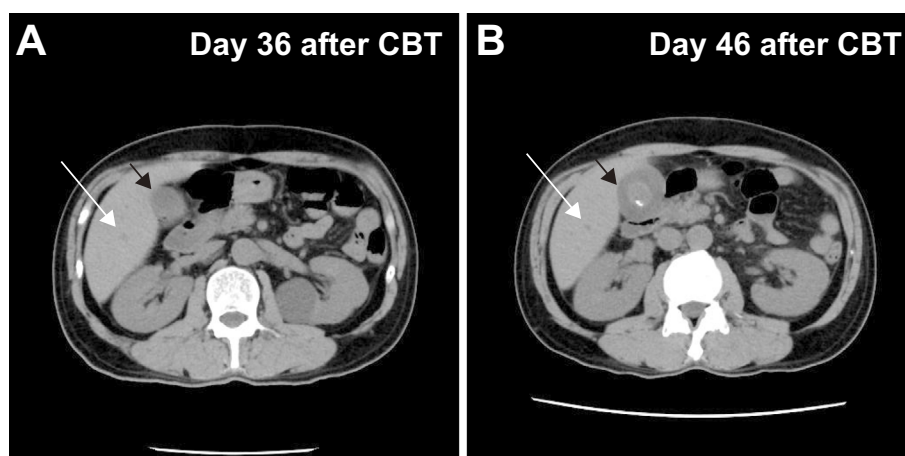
An unenhanced computed tomography (CT) scan showing mild thickening of the wall of the gallbladder (black arrow), poorly marginated low-density areas (white arrow) on day 36 (A), and the enlargement and severe thickening of the wall of the gallbladder (black arrow) on day 46 (B).
